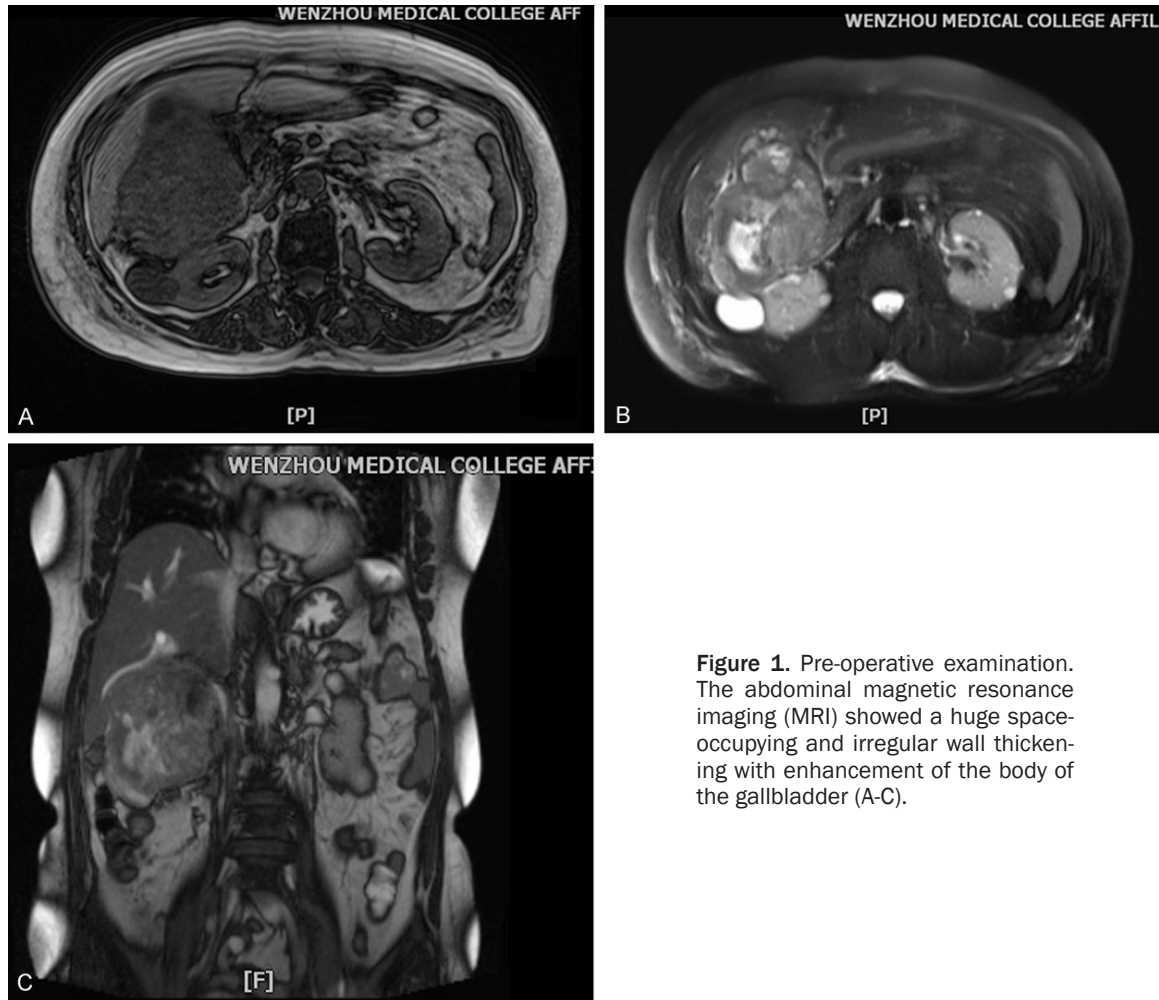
Pre-operative examination. The abdominal magnetic resonance imaging (MRI) showed a huge space-occupying and irregular wall thickening with enhancement of the body of the gallbladder (A-C).
